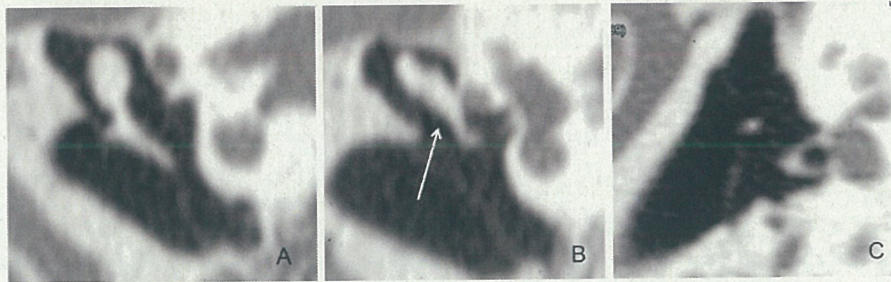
MPR images with 4-detector row CT scanner in an ear with traumatic ossicular discontinuity. The incus is dislocated as shown by the arrow. (A) Malleus, (B) incus, and (C) stapes.
